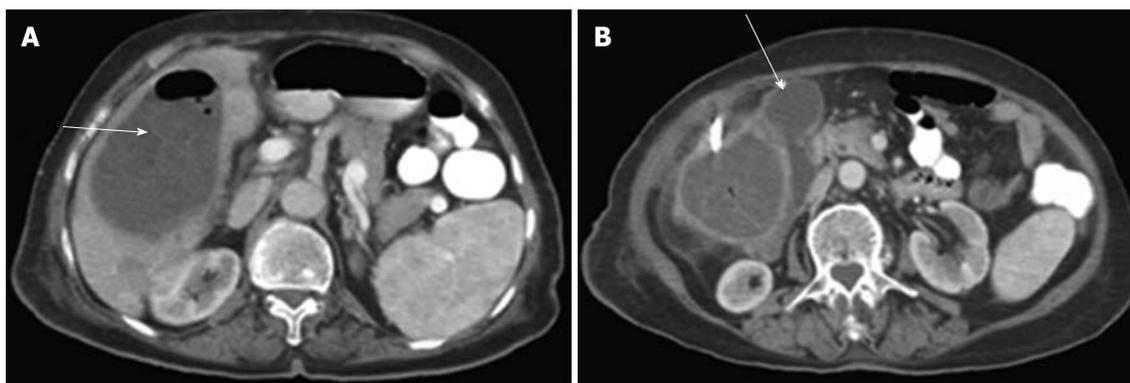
A case of acute cholecystitis complicated by hepatic abscess. A: Computed tomography (CT) scan shows a large intrahepatic abscess with air/fluid level within (arrow); B: CT-guided drainage of the hepatic abscess which is seen adjacent to acute cholecystitis (arrow).
